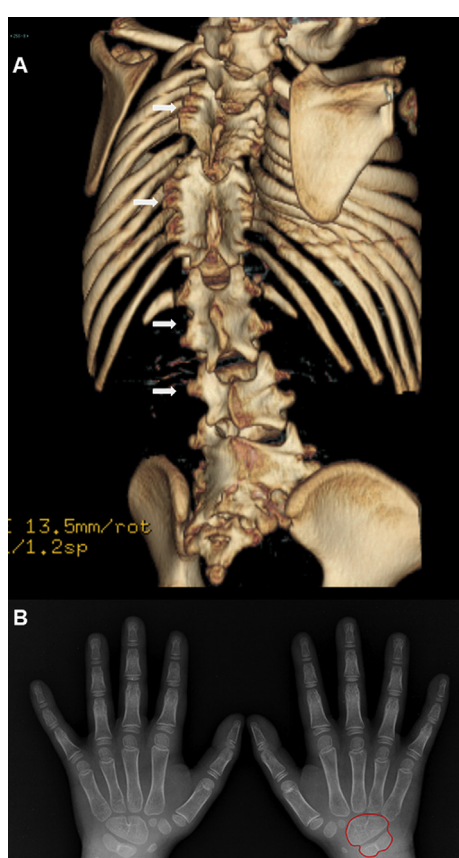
A) 3D reconstruction of a CT scan showing multiple vertebral body fusions. The fusion of posterior elements resembles bats with their wings expanded (white arrows); B) conventional radiograph of the hands (posterior-anterior projection) showing a bilateral identical carpal coalition of the hamate-capitate and lunar-triquetral bones that resembles ladybug shape.
